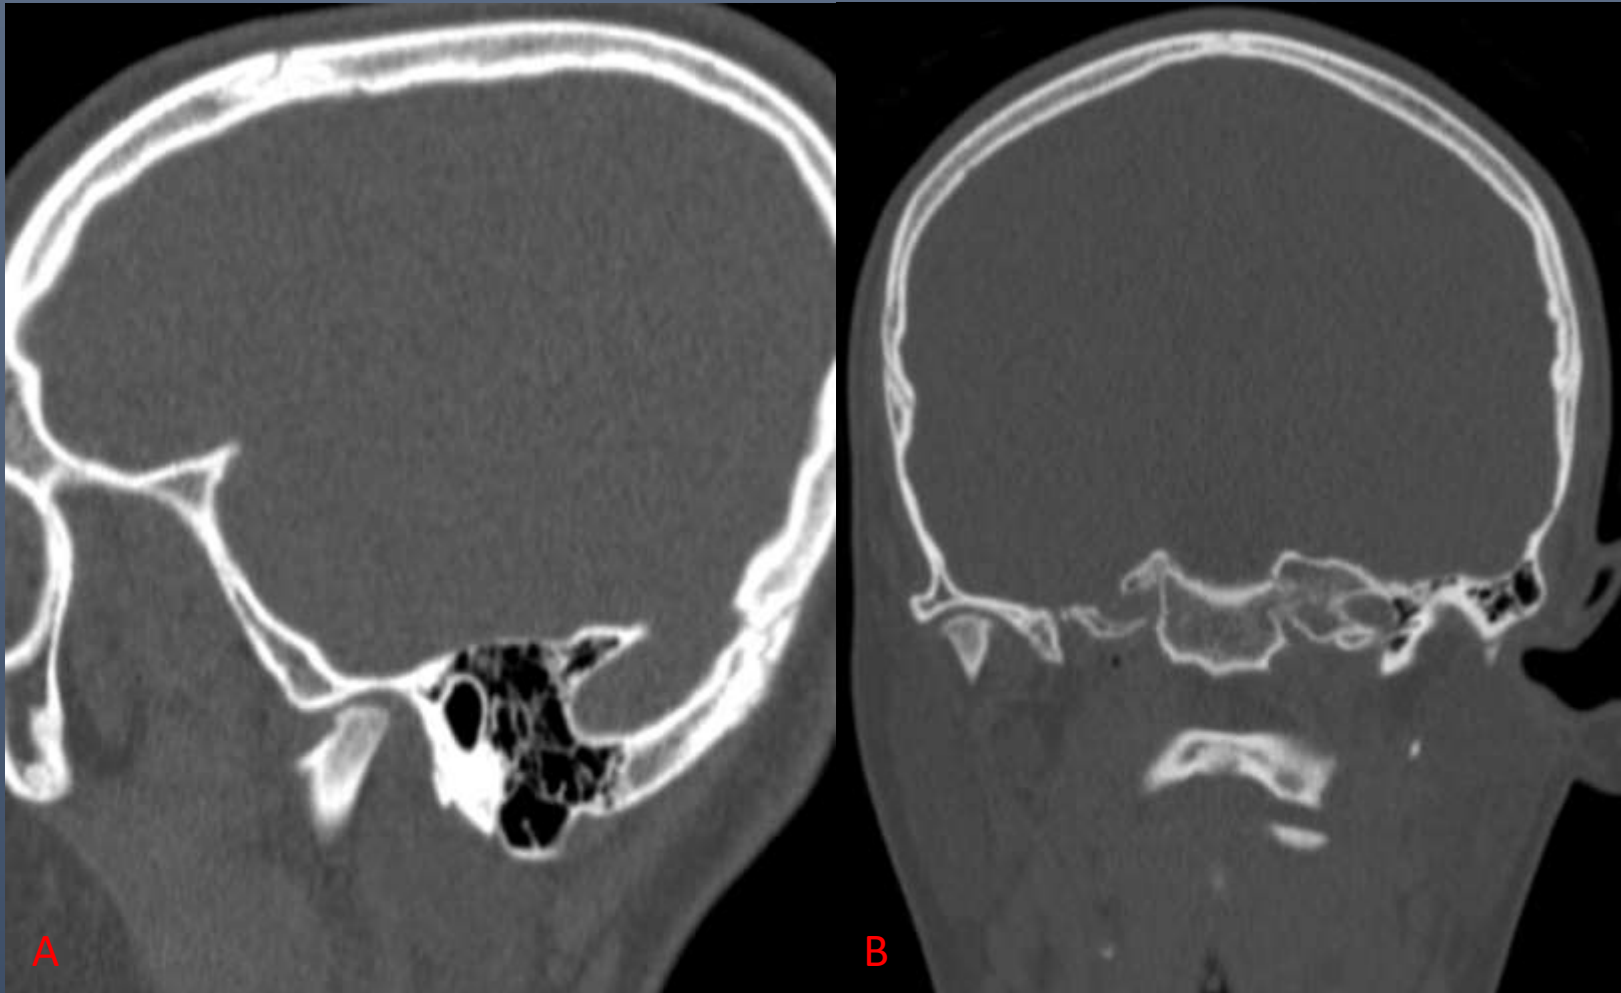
A: Sagittal and B: Coronal CT images demonstrate flattening and irregularity/small erosions of the right mandibular condyle.
